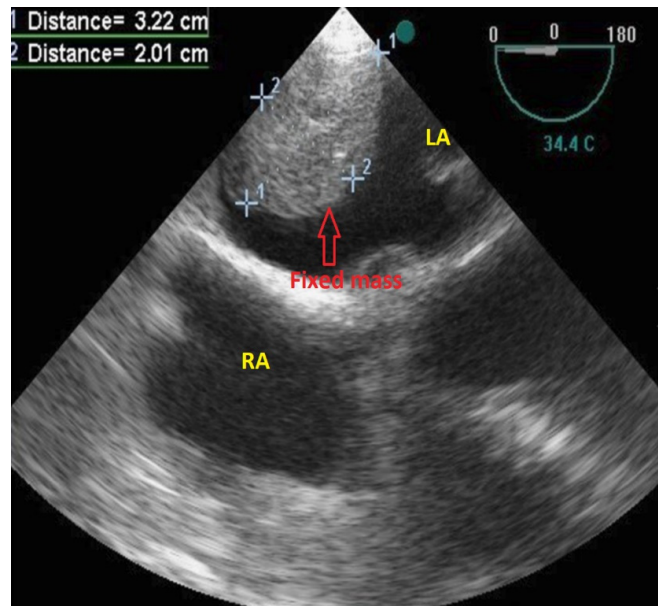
Trans esophageal echocardiography that showed a large (3.2*2cm) fixed mass in LA
